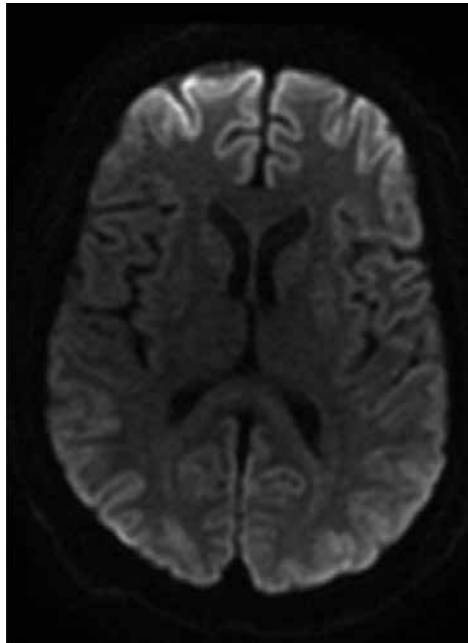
MRI of a 43-year-old patient who sustained an acute respiratory arrest secondary to severe respiratory failure from seasonal influenza. He was transferred immediately to an ECMO center and required 14 days of veno-veno ECMO support. Despite successful weaning from ECMO with good end-organ function, he remained in a coma. Post-ECMO MRI demonstrated an extensive diffusion defect consistent with severe anoxic brain injury/ischemia. Due to these findings and concerns for a poor long-term neurologic outcome, the family decided to withdraw support.
